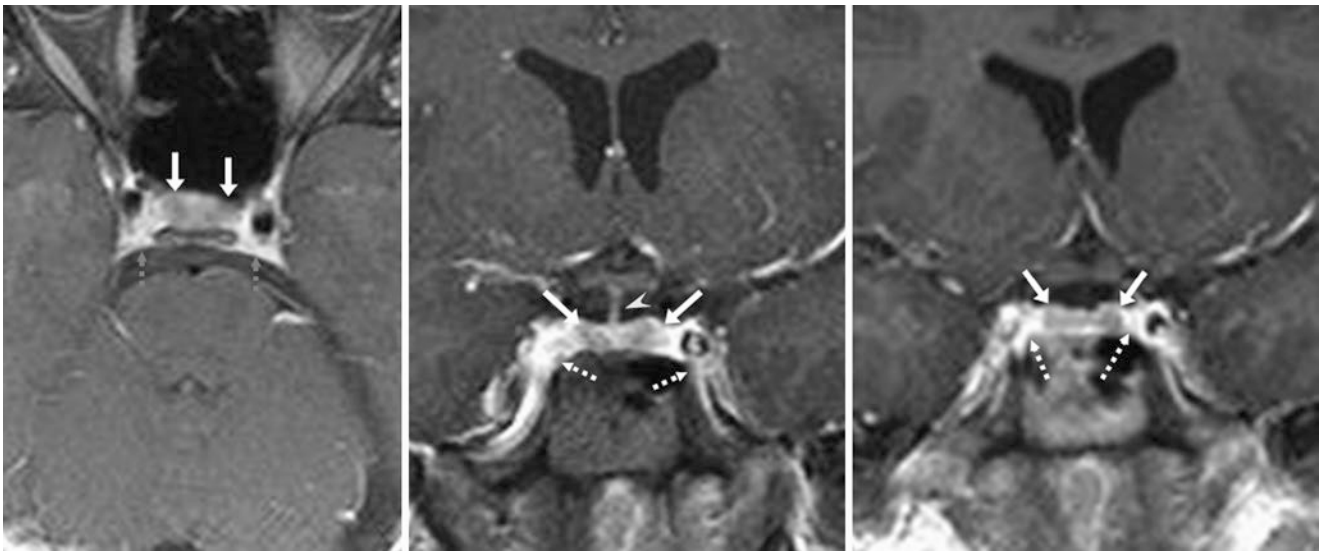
Normal lateral anterior lobe delayed enhancement. In a 13-year-old female with hearing loss (negative 1.5 T MRI), the lateral, peripheral portions of the anterior lobes (*arrows*) remain mildly hypointense on axial (*left*) and coronal (*middle and right*) images. The stalk
